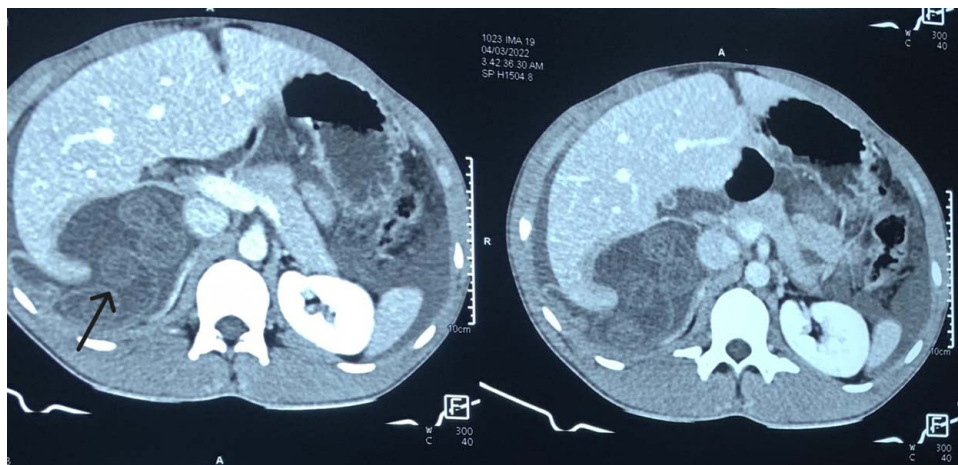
Contrast-enhanced computed tomography of the abdomen (arrow shows the cyst).
